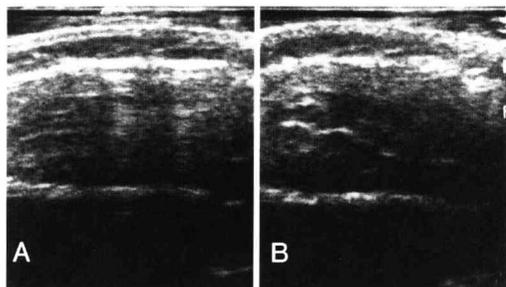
Ultrasound images of the masseter muscle corresponding to the scanning position.
